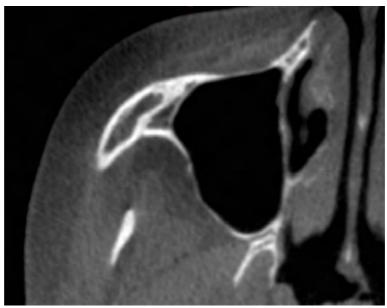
Sample data from an i-CAT, cone beam CT scanner. Close up of the maxillary sinus area. 0.25mm pixel size.
